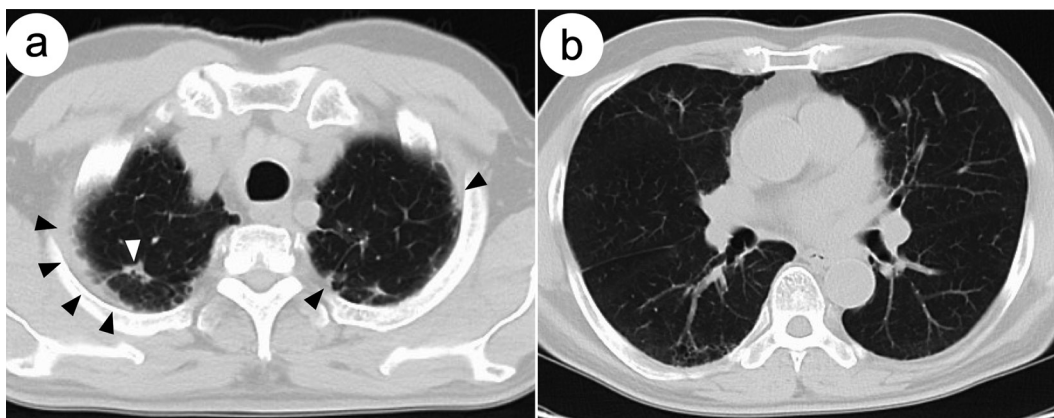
Chest computed tomography images before antitubercular treatment. Chest CT scan images showing: (a) inflammatory nodules (white arrow) and pleural thickening (black arrows) in the pulmonary apex regions, (a and b) emphysematous changes in the apical and middle lung fields. CT, computed tomography.
